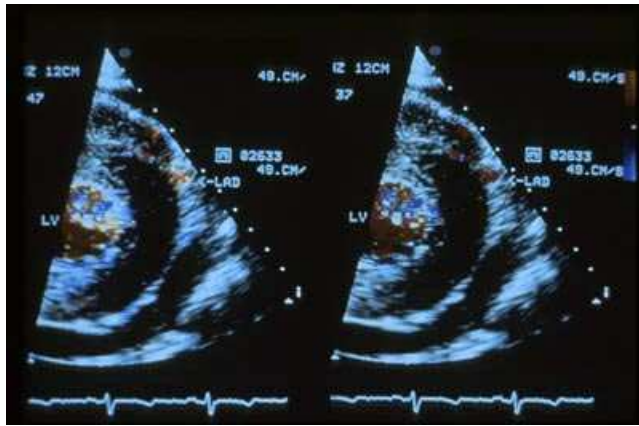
21 Parasternal short-axis view showing the left anterior descending coronary artery. The flow within the vessel is obscured by the surround tissue artifact in the panel A. The panel B shows good separation between flow and vessel wall.
